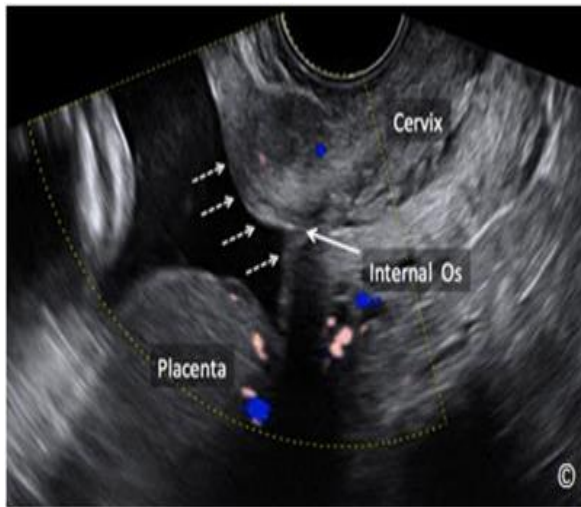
Transvaginal ultrasound with color Doppler at 32 weeks showing the absence of a vasa previa (dashed arrows) in a pregnancy that had a placenta previa in the second trimester. Note that the placenta is no longer covering the cervical internal os (labeled). The cervix and internal os are also labeled for image orientation.
